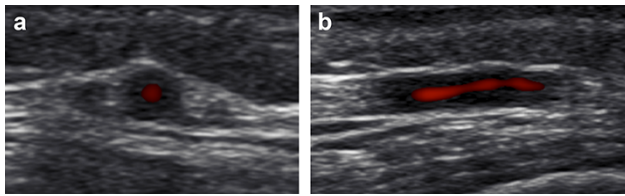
Ultrasonography showing wall thickening of the right temporal artery, halo sign (a, b).
